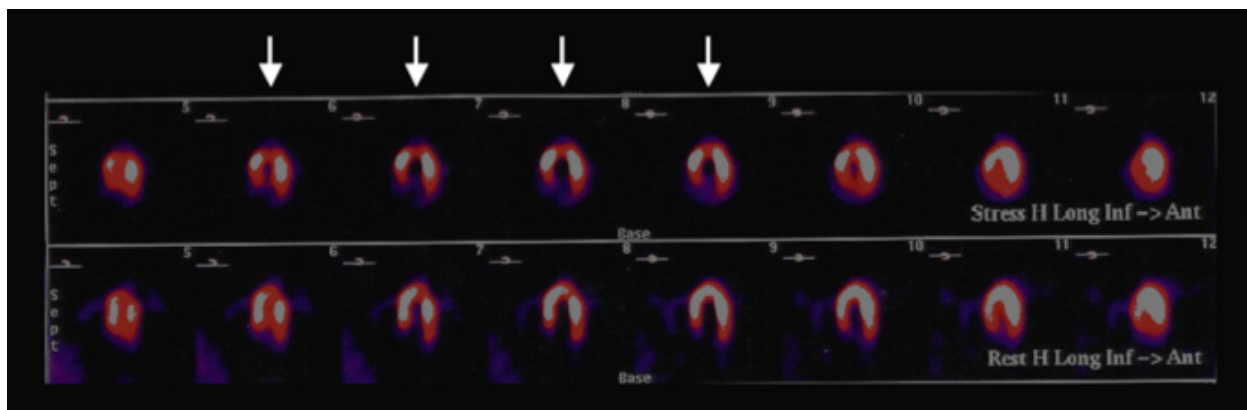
Typical example of SPECT-MPI scan positive for myocardial ischemia during mental stress. Stress images are in the upper row and baseline images are in the lower row. This subject displayed apical ischemia during mental stress, indicated by white arrows.
